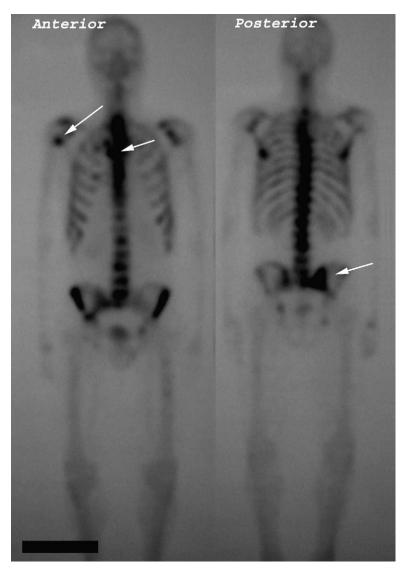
Whole-body bone scintigram. Arrows point to the most prominent areas of enhancement consistent with metastatic disease.
